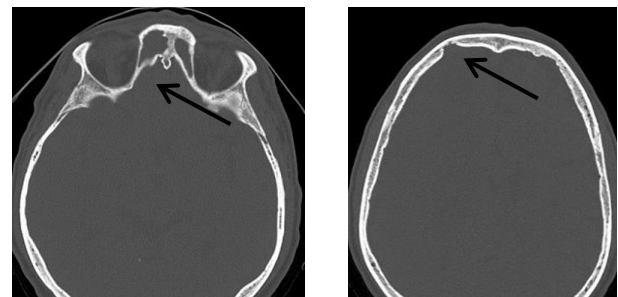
Axial CT Scan. Bone window. Right frontal sinus and right frontal bone osteolysis (black arrow).
